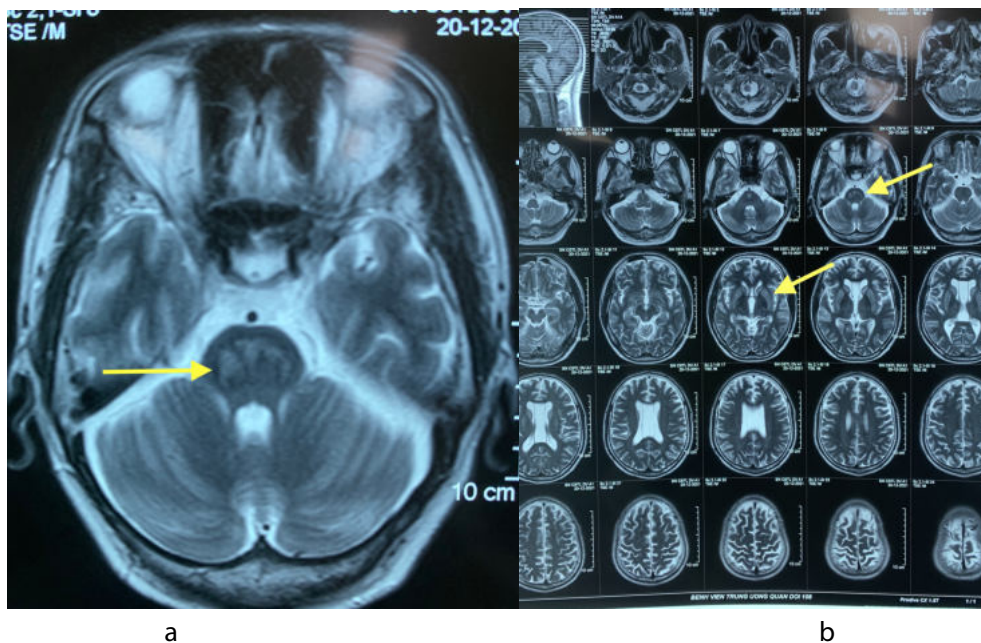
Brain MRI at 10th-day. Fig. 3a. Classic trident-shaped appearance in pontine. Fig. 3b. Image of damages in thalamic, pontine, lenticular and caudate nucleus.
